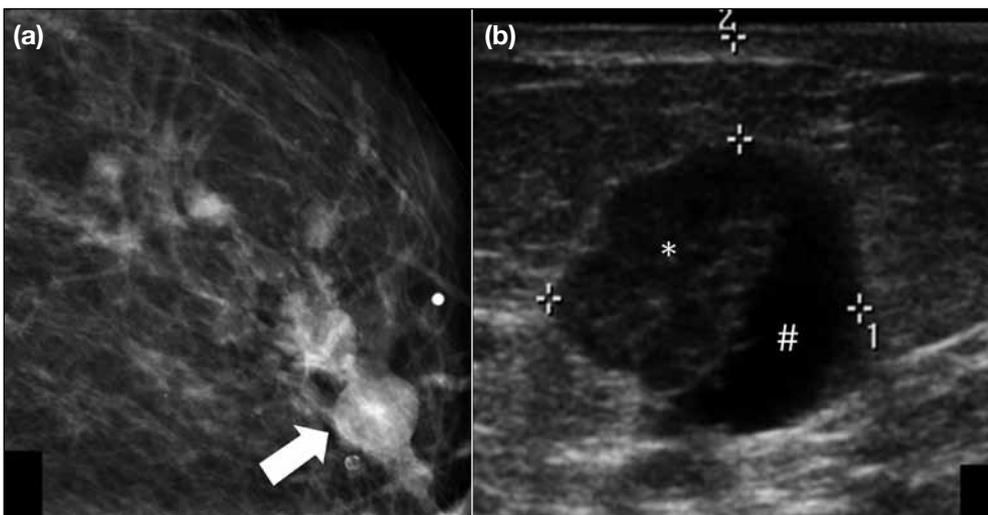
(a) Compression mammogram of the left breast of a 63-year-old woman showing an isodense oval mass (arrow) with obscured margins located in the upper quadrant of the breast, corresponding to the palpable feature of the mass (radiopaque marker on the skin). (b) Ultrasound image showing an oval mass, with circumscribed margins (calipers, region 1), complex solid (*) and cystic (#) pattern, and longest axis parallel to the skin, located at the junction of the upper quadrants of the breast.
